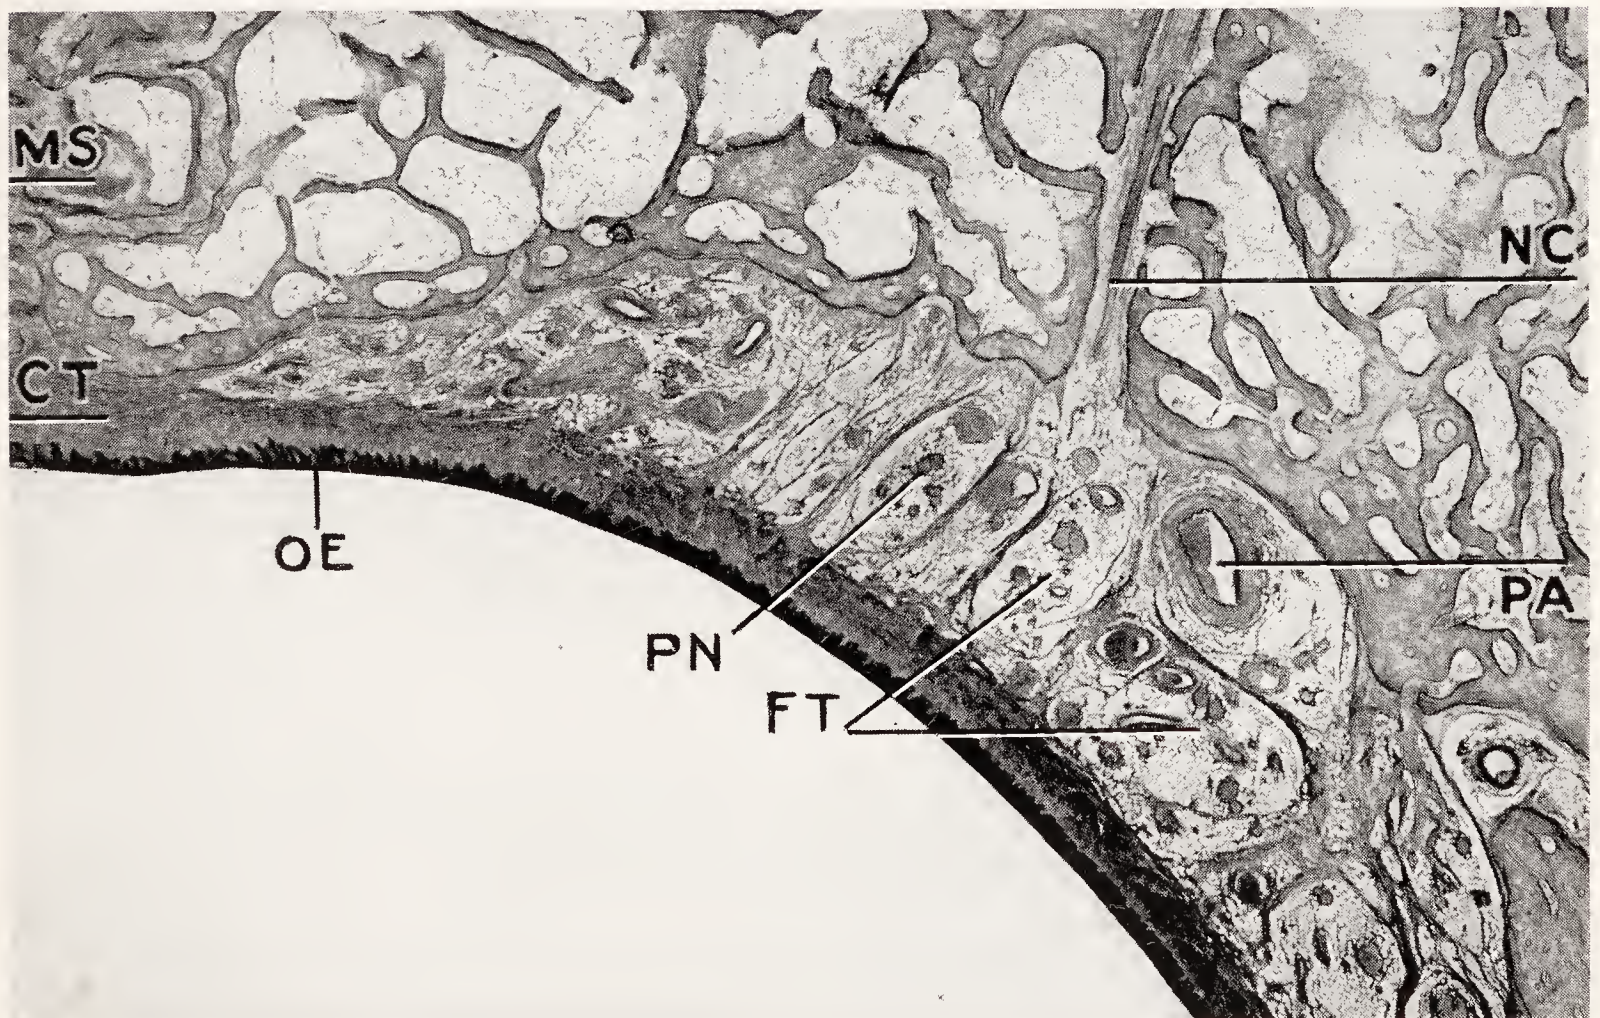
Area between maxillary ridge and maxillary suture. *PA*, palatine artery; *PN*, palatine nerves; *FT*, fat tissue; *CT*, fibrous connective tissue overlying the maxillary suture; *MS*, maxillary suture; *NC*, nutritional canal in the bone; *OE*, oral epithelium. (Pendleton, Jour. Am. Dent. Assn.)
